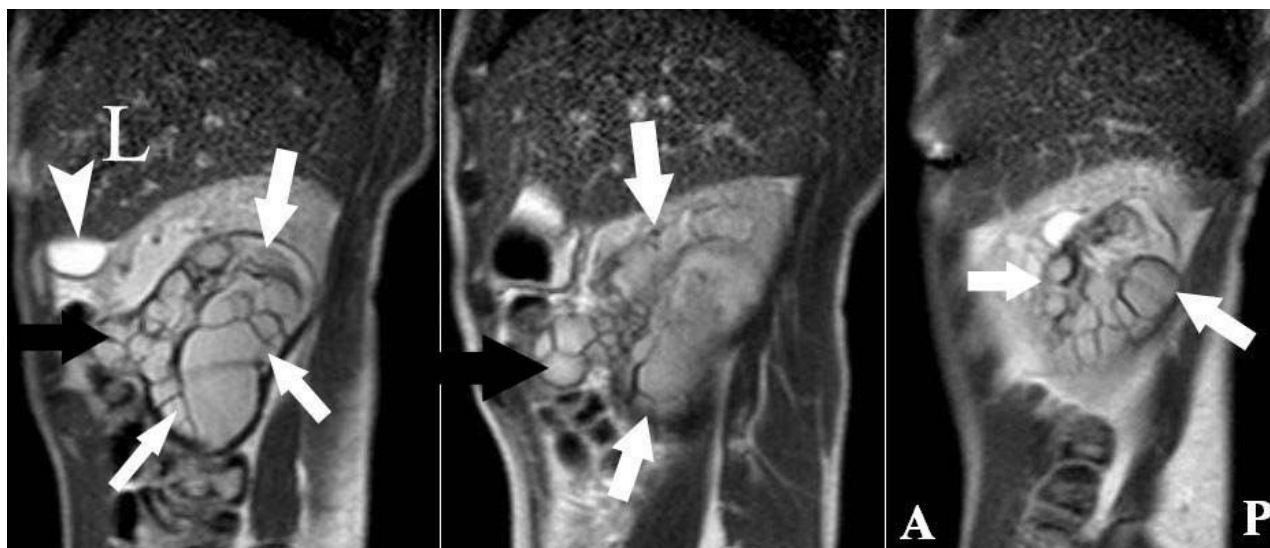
25 year old male with renal hydatid cyst. (A).Coronal (B) Axial T1W weighted image obtained on a 1.5 T MRI scanner. MRI showing hypointense lesion in the right kidney (arrows).
